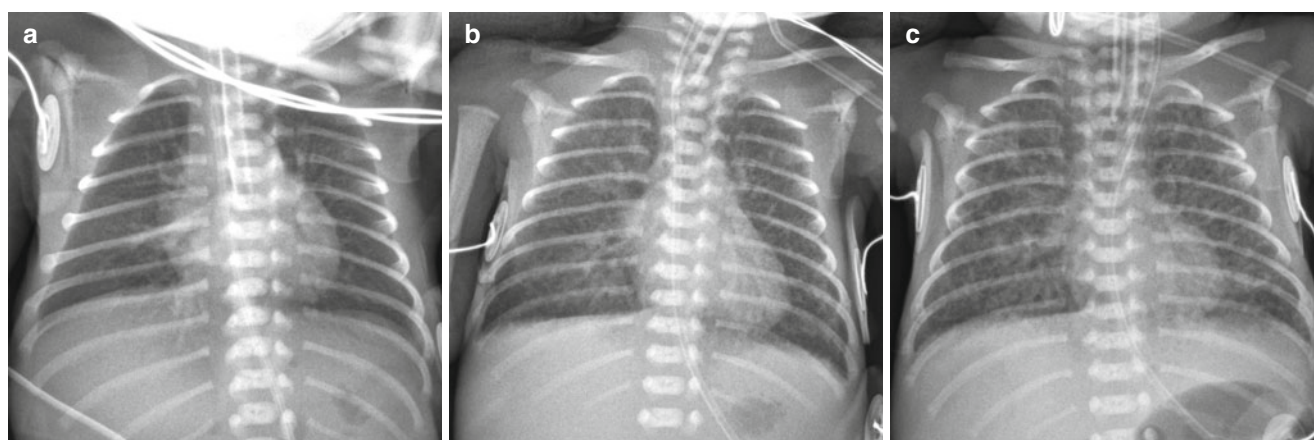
Immature lung syndrome in a profoundly premature neonate delivered at a gestational age of 23 weeks and 6 days with a birth weight of 590 g. (a) Anteroposterior chest radiograph obtained on the first postnatal day shows almost clear lungs and normal lung volume. (b) Follow-up radiograph obtained at 9 days shows diffuse faint
